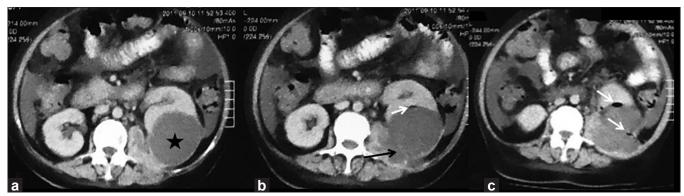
Contrast-enhanced computed tomography (CECT) abdomen and pelvis revealed hypodense lesion in the lower pole of left kidney (star in a), with air pockets (white arrows in b and c) visible within the lesion and in the perinephric tissues. Lesion was seen extending beyond the Gerota's fascia (black arrow in b), with perinephric fat stranding
